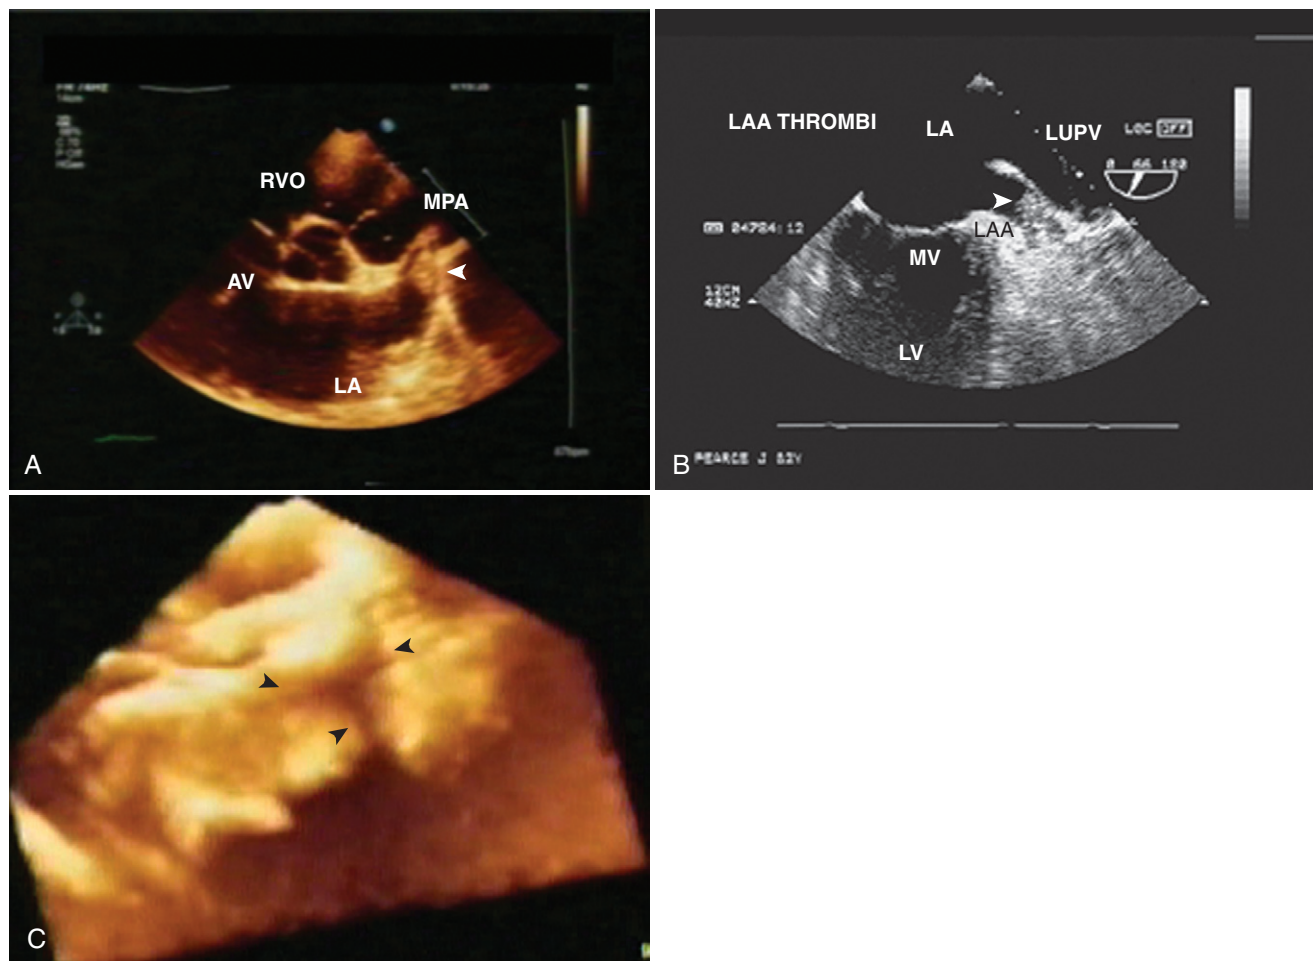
A, Two-dimensional transthoracic echocardiogram. *Arrowhead* points to a thrombus within the left atrial appendage (LAA). B, Two-dimensional transesophageal echocardiogram. The *arrowhead* points to a thrombus in the left atrial appendage. C, Three-dimensional transthoracic echocardiogram. *Arrowheads* point to individual lobes of the LAA visualized by cropping a three-dimensional dataset. AV, Aortic valve, LA, left atrium, MPA, main pulmonary artery; RVO, right ventricular outflow tract; LV, left ventricle; LUPV, left pulmonary vein; MV, mitral valve. (A, From Nanda NC, Domanski M: *Atlas of transesophageal echocardiography*, ed 2, Baltimore, 2007, Lippincott, Williams and Wilkins, p 78. B and C, From Karakus G, Kodali V, Inamdar V, et al: *Comparative assessment of left atrial appendage by transesophageal and combined two- and three-dimensional transthoracic echocardiography*, Echocardiography 25:918–924, 2008.)
